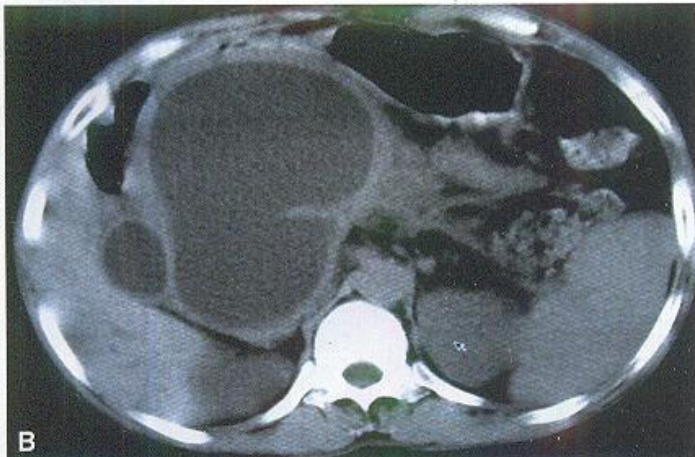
CT picture showing ascites.
